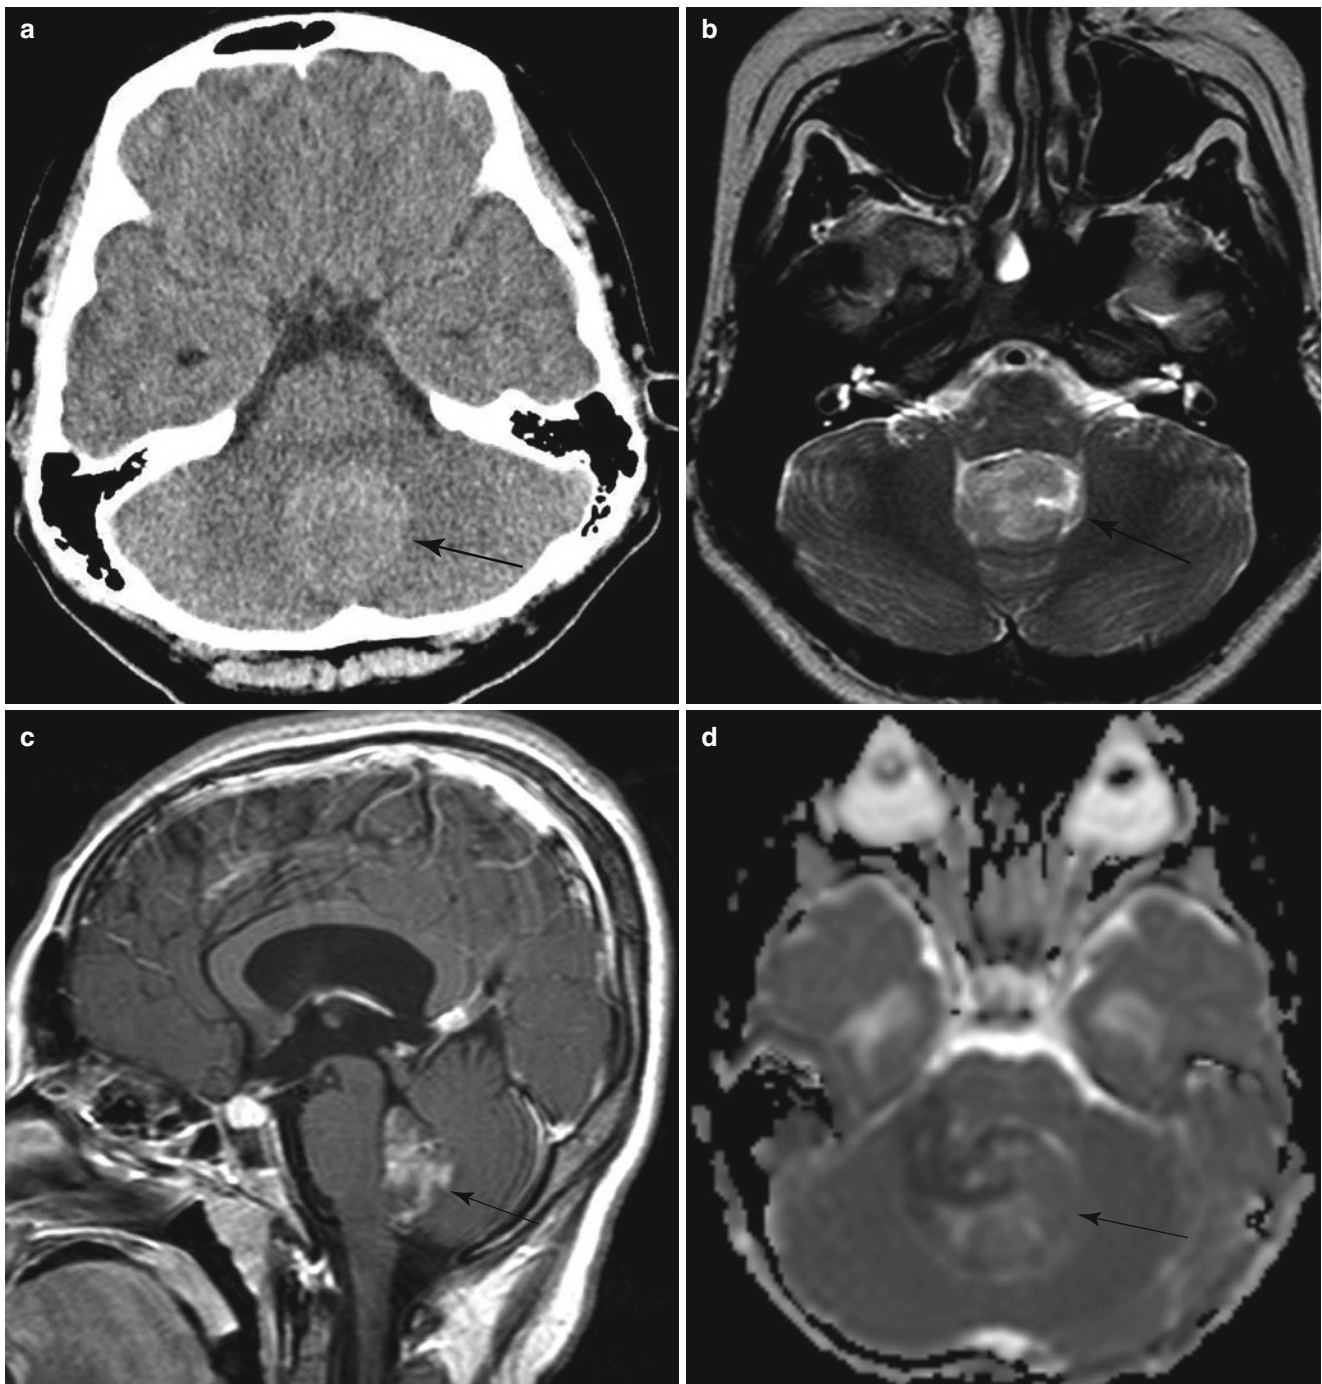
Medulloblastoma in an 11-year-old girl. (a) Noncontrast CT shows hyperdense midline cerebellar mass (arrow). (b) The mass (arrow) shows slight hyperintensity compared to the gray matter on T2-weighted image. (c) Postcontrast sagittal image reveals the mass
